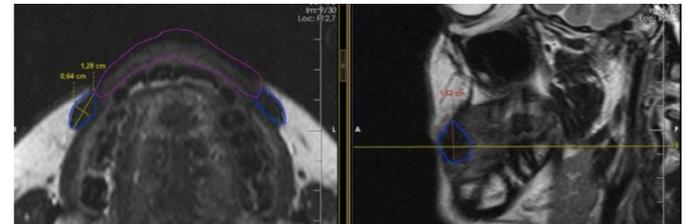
Magnetic resonance images of modiolus anguli oris labelled with blue lines at the corner of the mouth
